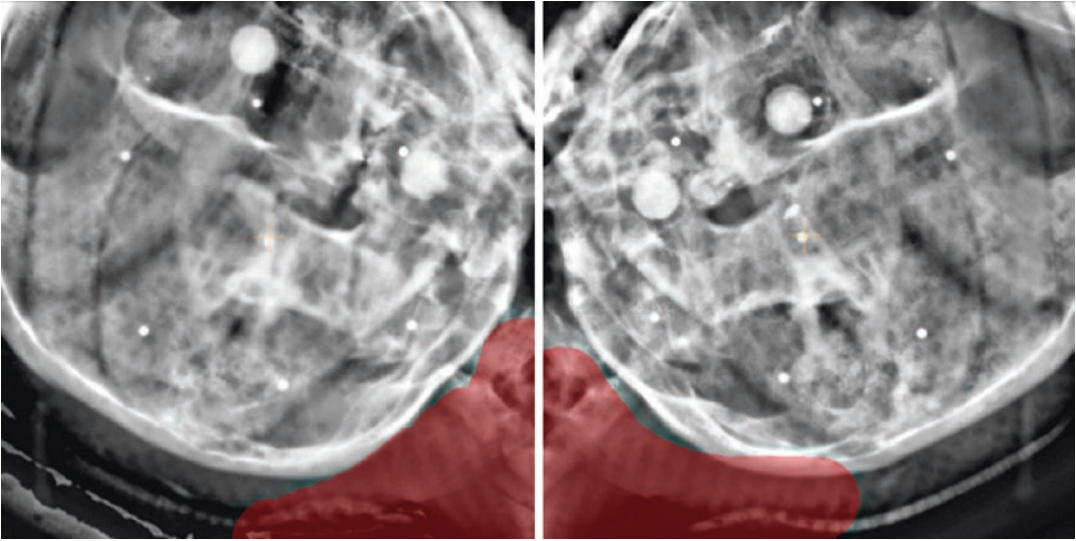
2D-3D registration of X-rays with dynamically generated DRR. The cervical spine is masked (*red*) to exclude from the registration process
